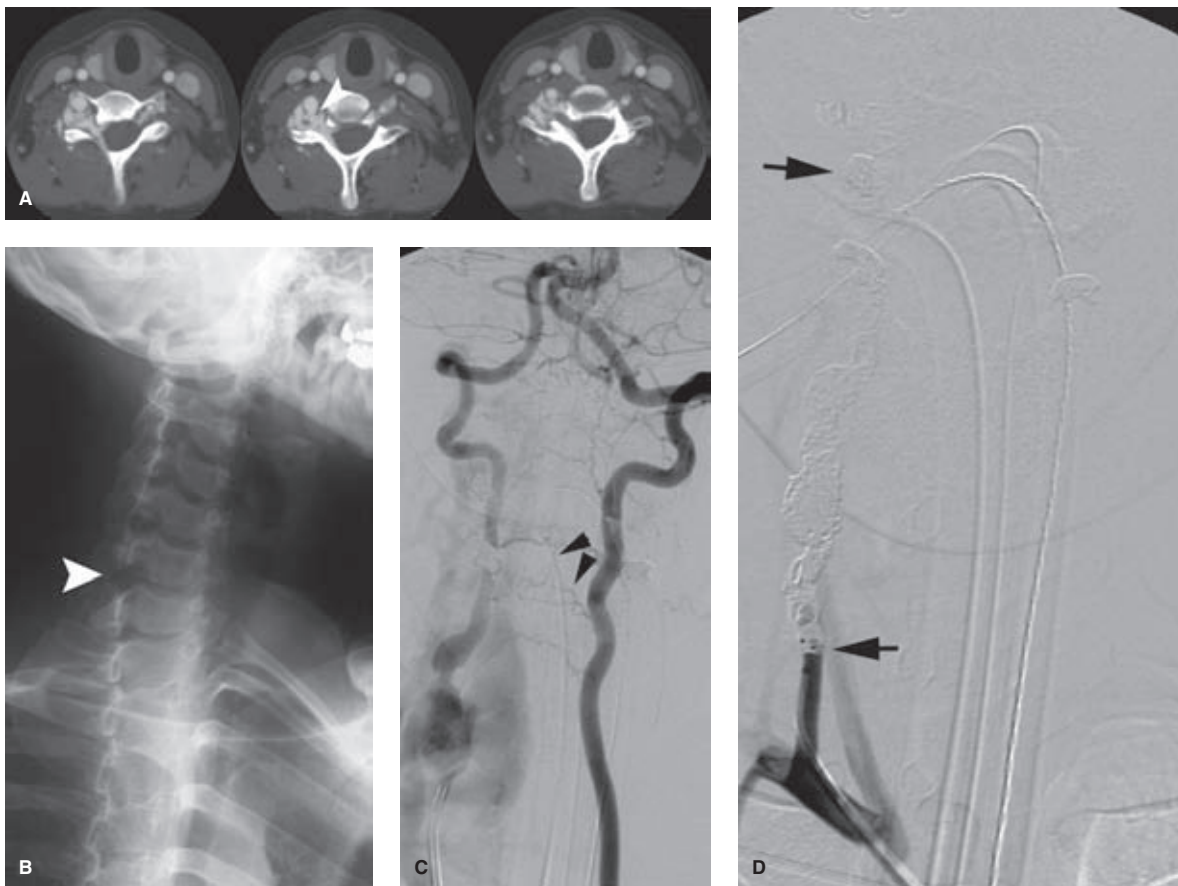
(A–D) Spontaneous right vertebral artery fistula. A young adult with subtle manifestations of neurofibromatosis Type I developed a loud bruit in association with right brachial plexus symptoms. Her CTA examination (A) showed the precise point of the spontaneous fistula (*arrowhead* in A), while the plain film (B) showed enlargement of the ipsilateral C6–C7 neural foramen (*arrowhead* in B). The left vertebral artery injection (C) with a second catheter in the right vertebral artery shows the obvious fistula, but the most important finding is the location of the anterior spinal artery (*arrowheads*) arising from the left and flowing retrogradely, through an arrangement of bilateral pedicles, to the right. This clears the way from a complete occlusion of the right vertebral artery with 0.018” and 0.038” coils (*arrows* in D) deployed from C1 to below the fistula in order to avoid antegrade transmission of thrombus from the stump above the occlusion site. Balloons would have been better for this case but were unavailable. A covered stent would also have worked possibly but would not have been as tested in terms of long-term safety compared with this simple treatment.
